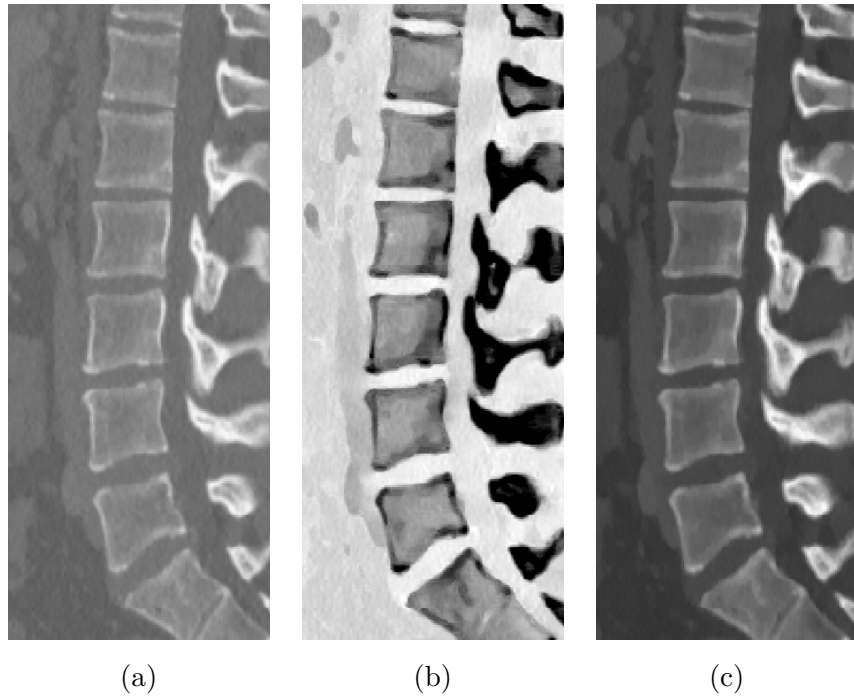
Example of different types of images, no spinal pathologies, (a) - conventional CT, (b) calcium suppress at 25 %, (c) - virtual monoenergetic image at 40 keV.
